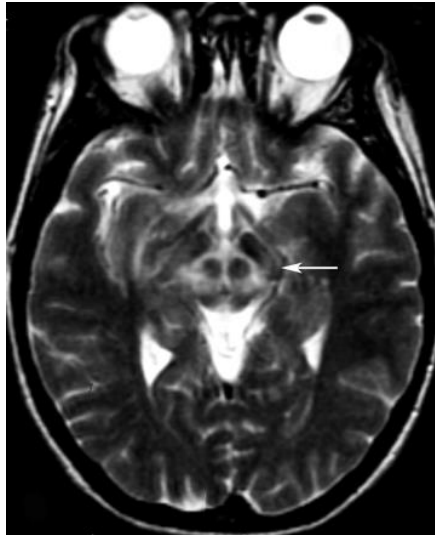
Panda face on MRI - classic for a patient with Wilson's disease and copper deposits in the brain (from Jacobs, 2003)
